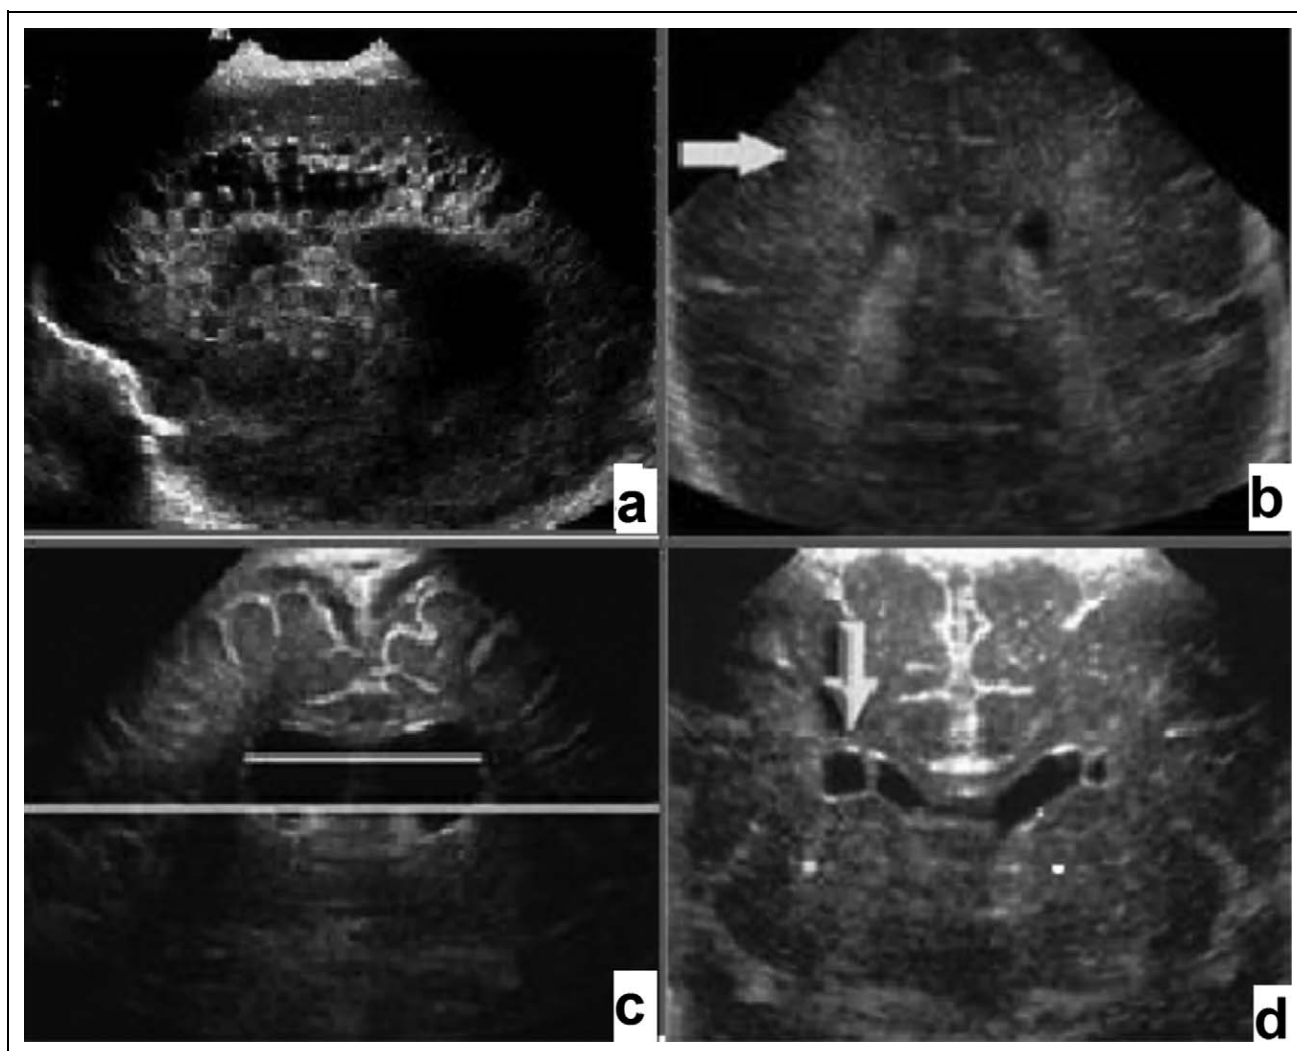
Cranial ultrasonographic scan images demonstrating (A) cystic periventricular leukomalacia, (B) periventricular echodensities, (C) ventricular dilation, and (D) pseudocyst.
